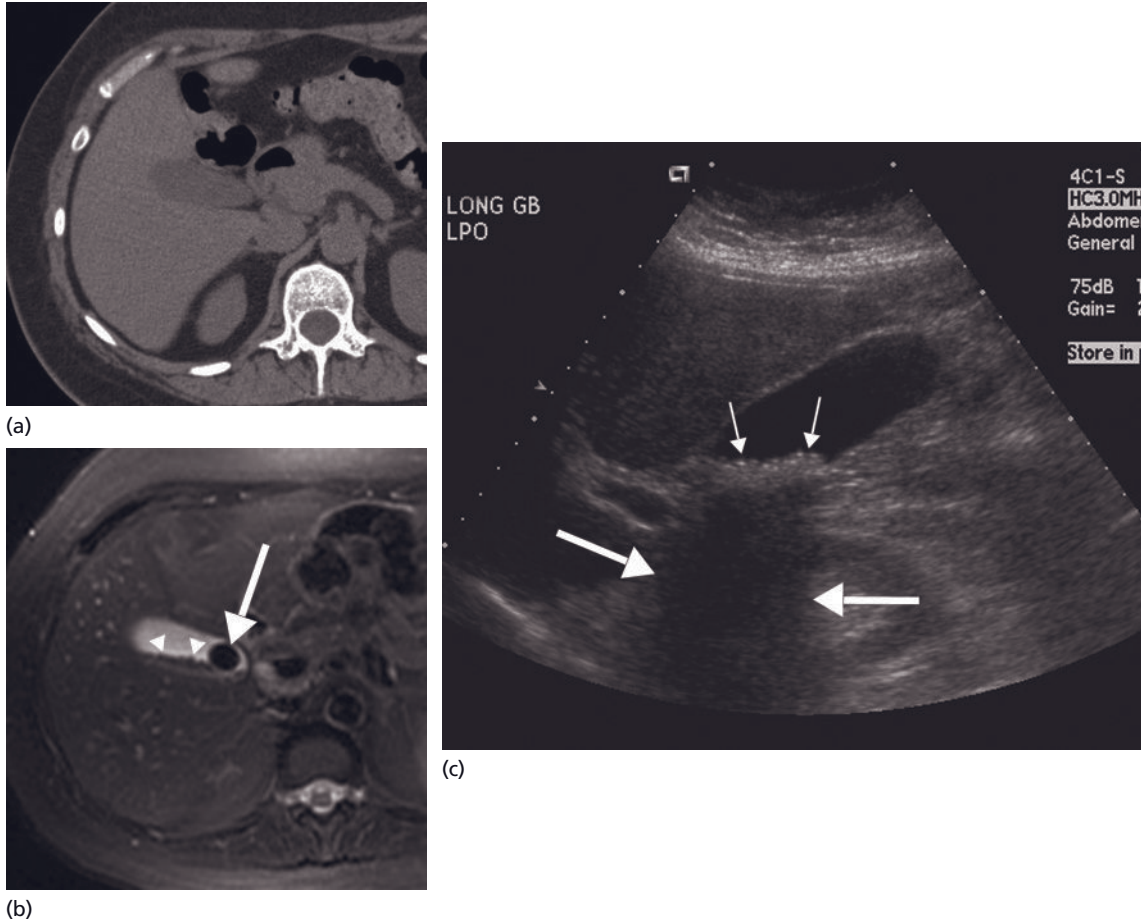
Cholelithiasis. (a) Non-enhanced CT without evidence for gall stones, as most are not radiopaque. (b) However, the corresponding axial, T2-weighted MR image readily shows numerous small gall stones (arrowheads) and a single, larger stone (arrow). (c) Ultrasound image in the same patient also demonstrates numerous, layering echogenic stones (arrows) with characteristic hypoechoic distal shadowing (arrows).
